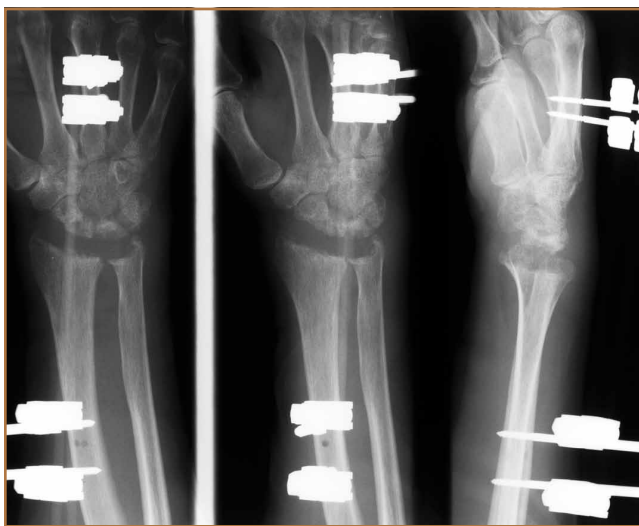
Postoperative radiographs at 6-week follow-up demonstrating distraction by external fixation.
